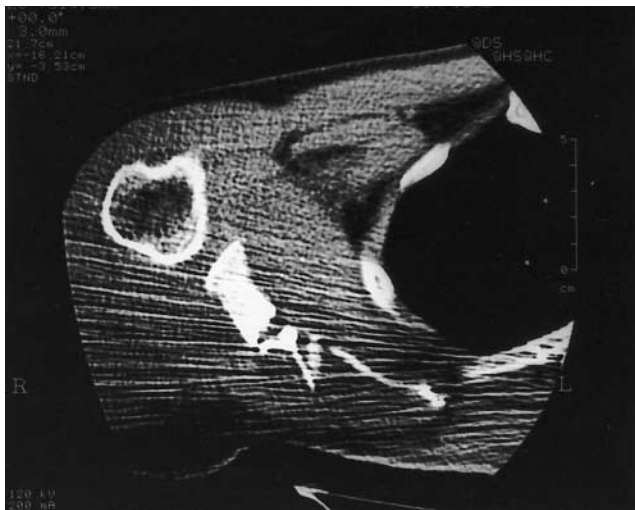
Computed tomographic scan, left shoulder
